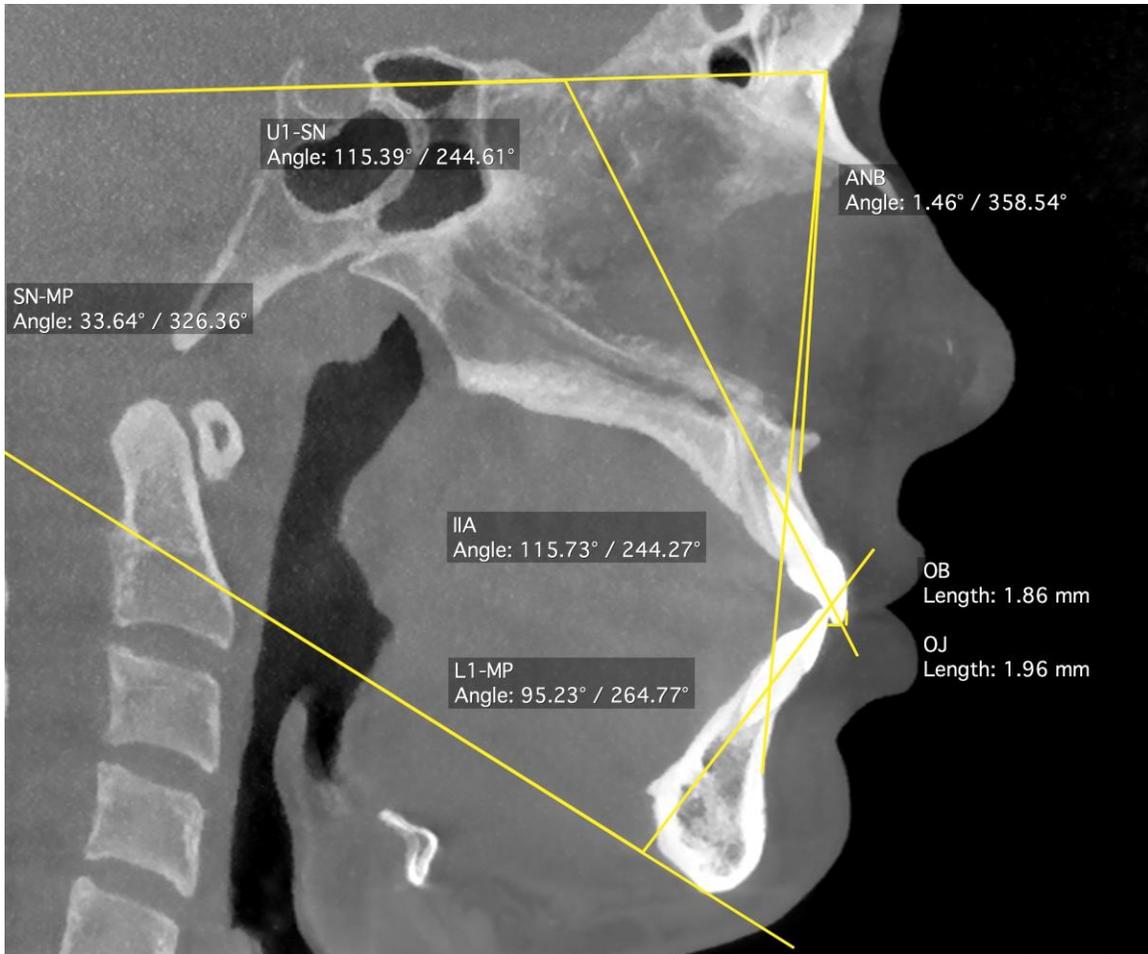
Cephalometric Measurements from CBCT
